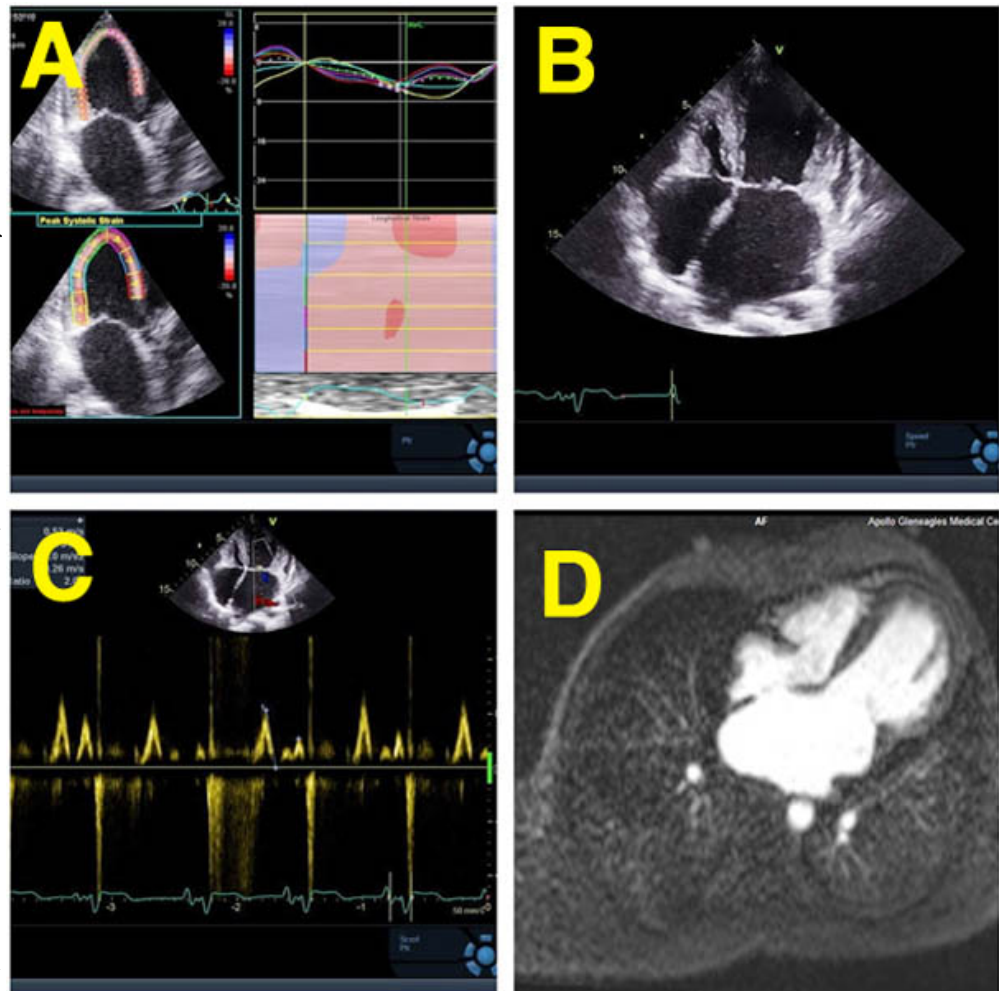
Systolic dysfunction with average global longitudinal strain = -4.5%. (B) Massive biatrial enlargement. (C) Restrictive ventricular physiology with E/e' = 2.0. (D) Cardiac MRI showed a lack of late gadolinium enhancement in the apical region, thus favouring cardiac amyloidosis over familial RCM.
